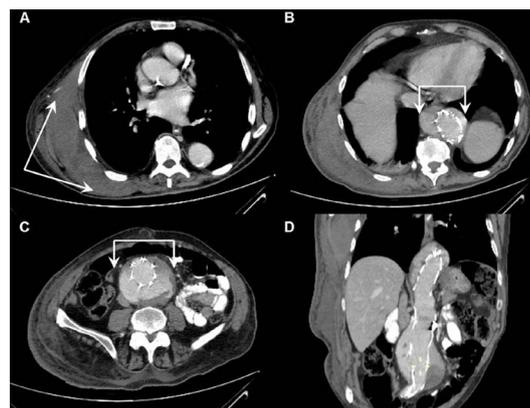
Chest wall haematoma and thoracoabdominal aortic aneurysm with endoleak. Contrast enhanced CT images of the chest and the abdomen show an extensive right chest wall haematoma (A, arrows) and large thoracoabdominal aortic aneurysm (B and C, arrows). The extent of the stented aneurysm is demonstrated on the oblique coronal reformat (D). Contrast is noted in the partially thrombosed enlarged aneurysmal sac, indicating the presence of an endoleak.
